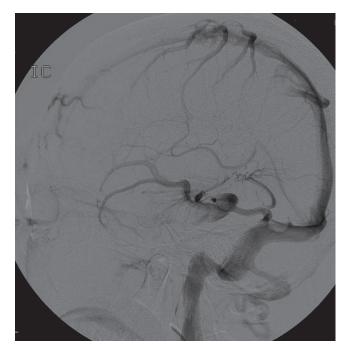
A case of developmental venous anomaly (DVA) with varix. A 49-year-old woman complaining of intermittent headaches underwent cerebral angiography to evaluate a vascular lesion discovered on MRI (not shown). Angiogram of the left internal carotid injection (lateral view) in the venous phase showing varix formation at the venous outlet of DVA at the vein of Labbé.
